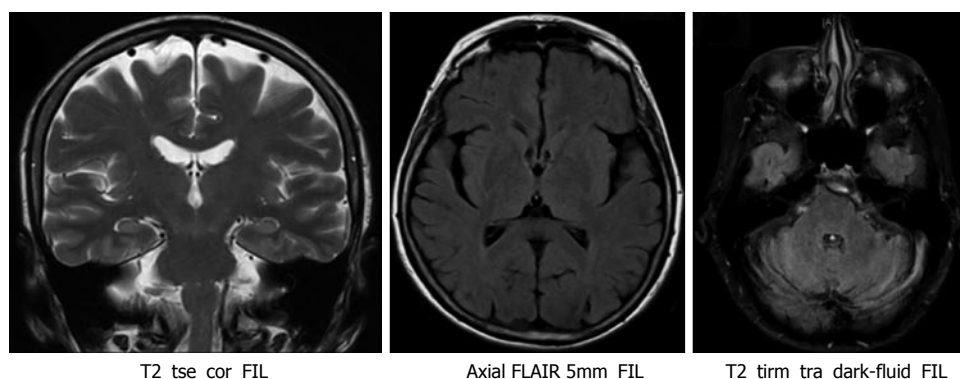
T2, TIR and FLAIR magnetic resonance imaging of the patient 1, it does not show abnormal findings. FLAIR: Fluid attenuated inversion recovery.
